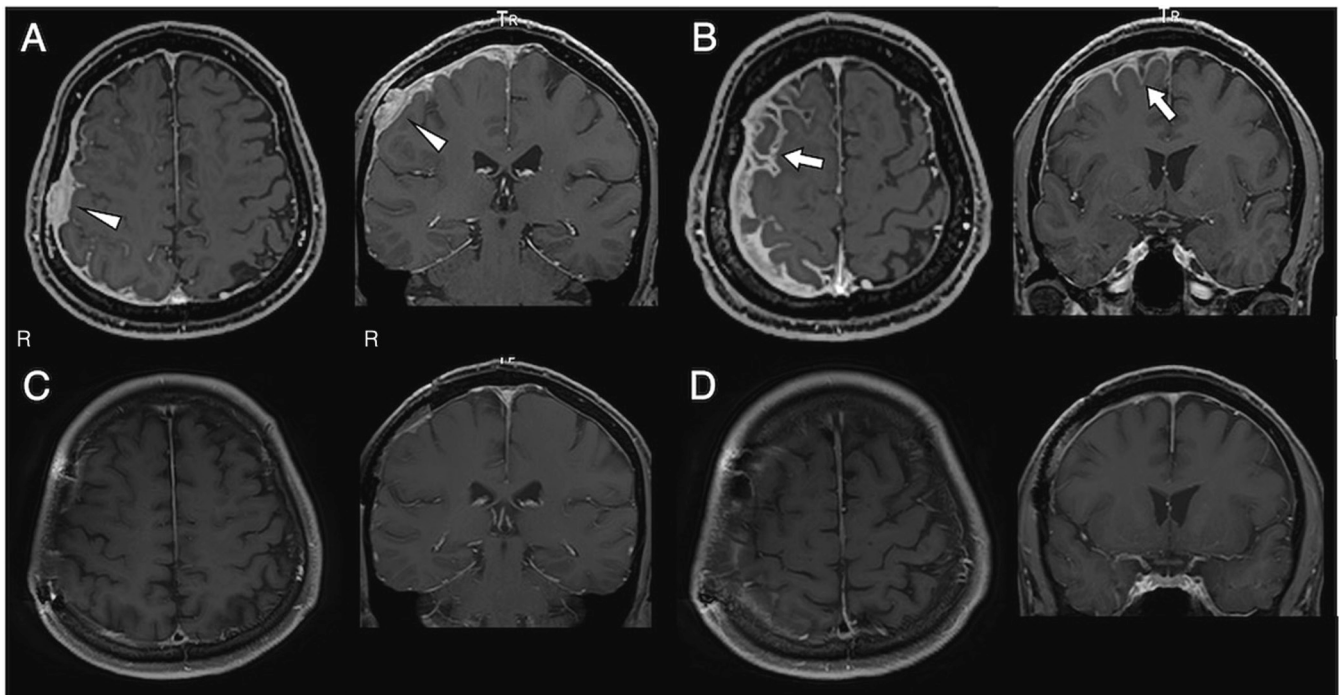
(A) Post-gadolinium T1-weighted images show pachymeningeal enhancement over the right frontoparietal convexity and a tumor-like lesion contiguous with the dura (arrowheads). (B) Marked leptomeningeal enhancement is shown in the right hemisphere (arrows). Enhancement of the interhemispheric sulci is also observed. (C, D) After 2 months of corticosteroid treatment, the pachymeningeal enhancement significantly improved and the pseudotumor disappeared along with surgical resection.
